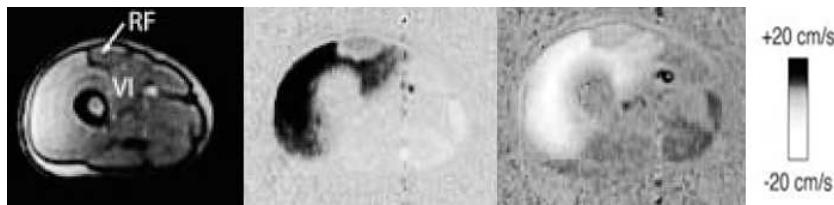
Cine phase-Contrast MRI of the thigh during knee flexion/extension [ABGD02]
